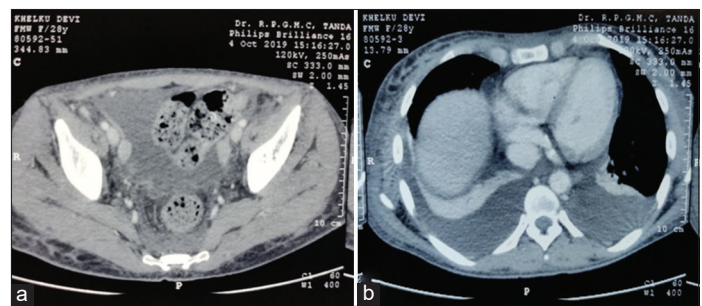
Contrast-enhanced computed tomography abdomen showing (a) gross ascites and (b) bilateral effusion
